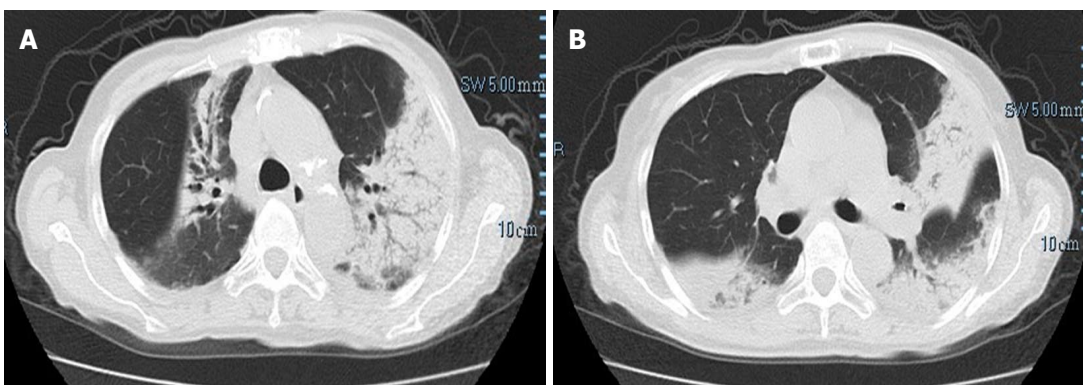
Repeat chest computed tomography scan showed an increase of the nodules and patchy infiltration after 2 wk antibacterial and antifungal treatment. Dyspnea deteriorated and no improvement was observed.
